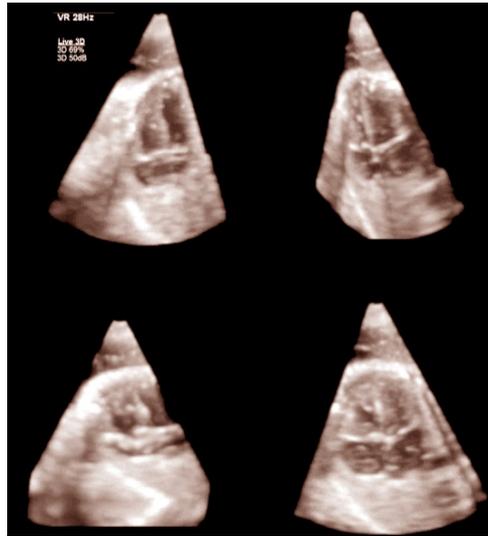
This is a real-time 4D volume examination of the fetal heart using the maxtrix array 4D probe. The images are of the fetal heart taken using different orientations of the cut plane as it passes through the four-chamber view. Because the ultrasound volume dataset is acquired simultaneously in all planes (X, Y, and Z), the volume rate is higher (28 volumes/second) than when using the mechanical array probe (6 volumes/second).
